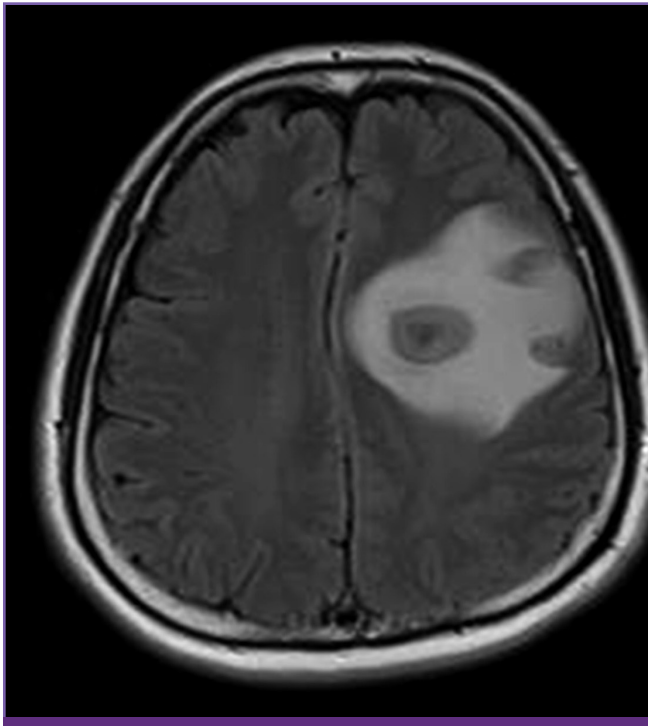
Initial brain MRI shows a 3.5 cm necrotic mass with peripheral enhancement in the left frontoparietal lobe, with perilesional edema and midline shifting.
